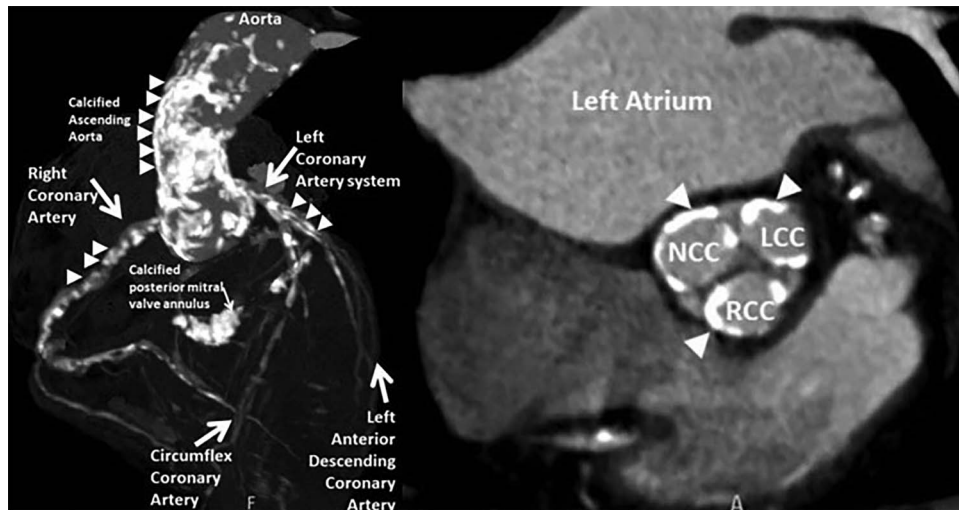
CT assessment of the heart and ascending aorta (left) shows extensive calcification (dense white, arrowheads) of the labeled structures; (right) shows calcification of the three leaflet aortic valve cusps (LCC, left coronary cusp; RCC, right coronary cusp; NCC, non-coronary cusp) causing severe AS.
